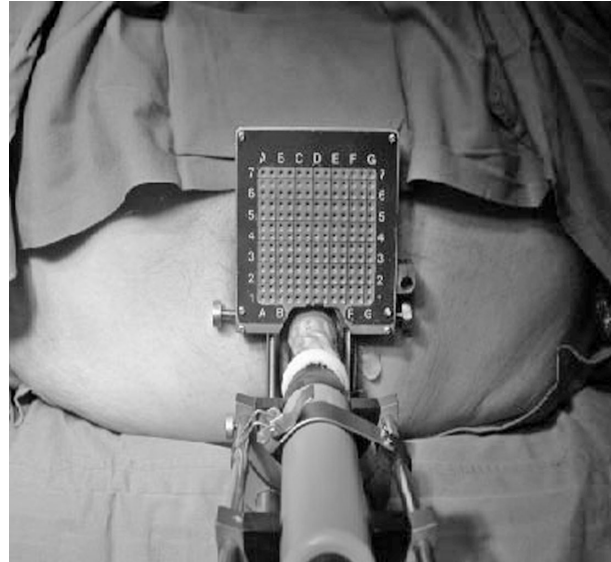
Patient set-up for volume study, showing ultrasound probe and template
